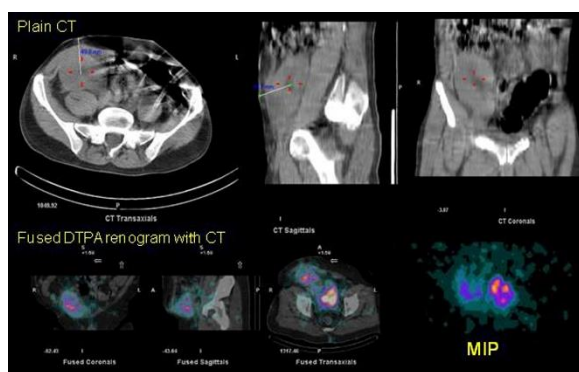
CT depth measurements of renal allograft in DTPA transplant renogram.
